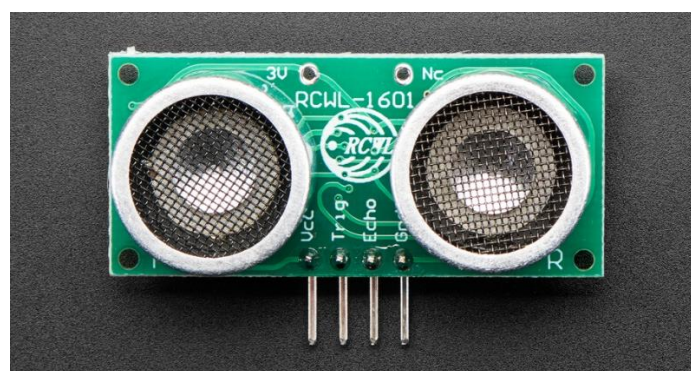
Ultrasonic sound sensor (RCWL-1601) [58].
